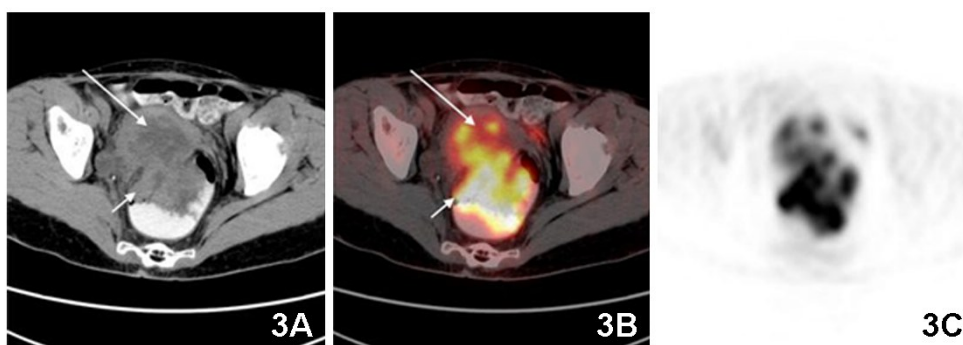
Axial images obtained from <sup>18</sup>F-FDG PET/CT in a 65-year-old female patient diagnosed with RMAC<sup>[49]</sup>
